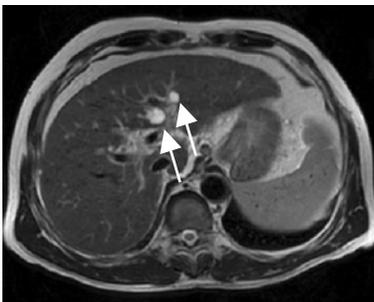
Hepatic cysts (left: T2-WI, right: DWI; black and white inversion)
